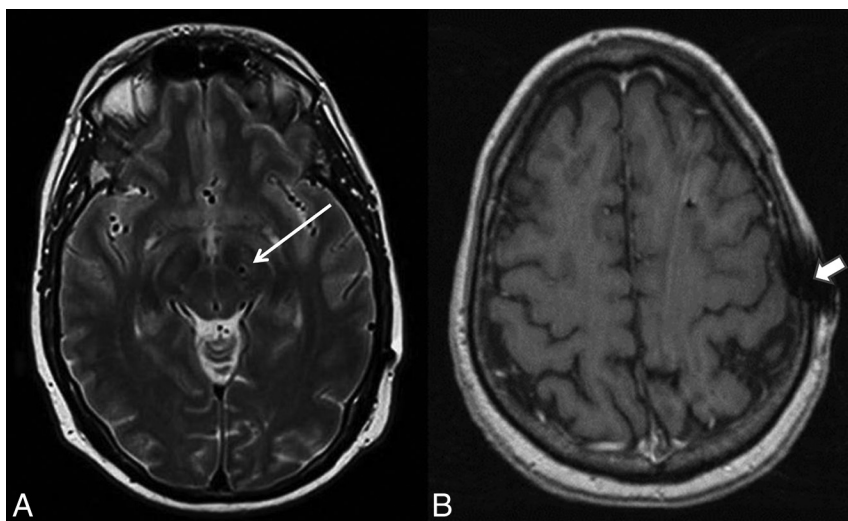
A, Susceptibility from the electrode was very minimal within the adjacent brain parenchyma on T2-weighted images (arrow). B, Device-related local susceptibility in the scalp at the site of electrode entry was seen in most cases on the MPRAGE sequence and was not thought to affect image quality. Additionally, a minority of cases showed artifacts likely attributable to stimulated echoes arising from peripheral fat on MPRAGE images only (arrowhead). Overall, all images were judged to be adequate for presurgical guidance.
